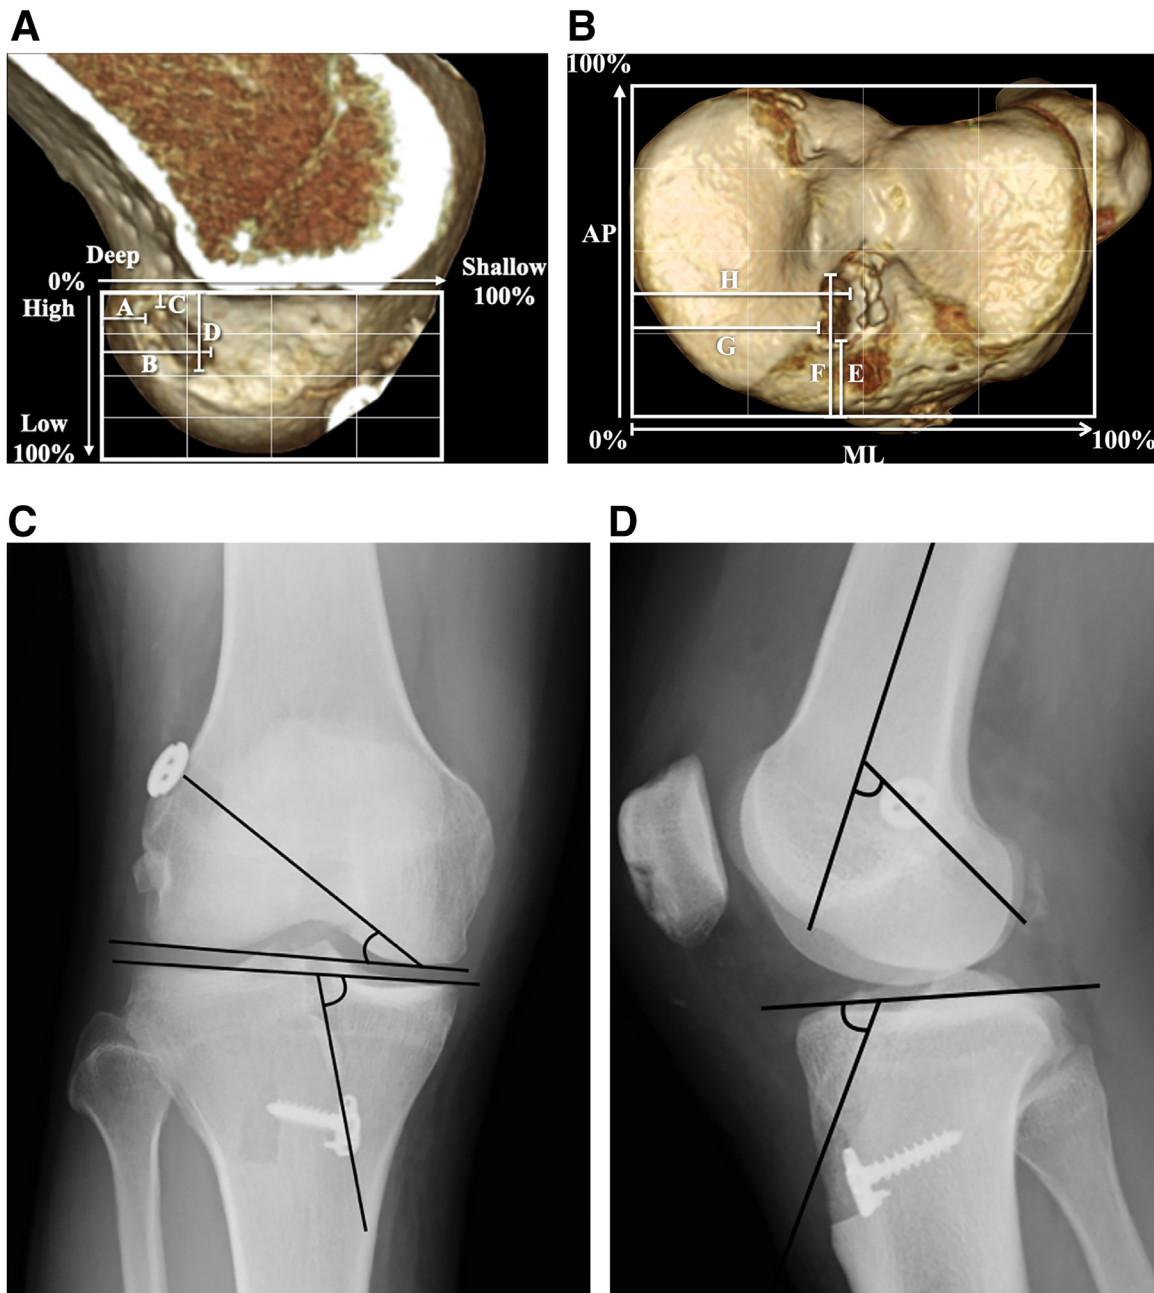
Measurement of tunnel location on three-dimensional computed-tomography and tunnel angles on plain radiography of the right knee. (A) Locations of the deep and shallow wall of the femoral tunnel were defined as the percentages of the distance from the most deep and shallow contour in reference to the total length of the lateral condyle parallel to the Blumensaat's (A and B). Similarly, locations of the high and low wall of the femoral tunnel were defined as the percentages of the distance from the intercondylar roof, with respect to the total depth of the intercondylar notch perpendicular to the Blumensaat's line (C and D). (B) Locations of the anterior and posterior wall of the tibial tunnel were defined as the percentages of the distance from the most anterior and posterior contour with respect to the anteroposterior (AP) length of the tibial plateau (E and F). Similarly, locations of the medial and lateral wall of the tibial tunnel were defined as the percentage of the distance from the most medial and lateral contour with respect to the mediolateral (ML) width of the tibial plateau (G and H). (C) The femoral and tibial tunnel angles were defined on anteroposterior radiography as the angle between the respective tunnel axes and joint surfaces. (D) The femoral tunnel angle on lateral radiography was defined as the angle between the femoral tunnel axis and the femoral shaft axis. The tibial tunnel angle on lateral radiography was defined as the angle between the tibial tunnel axis and the tibial joint surface.
